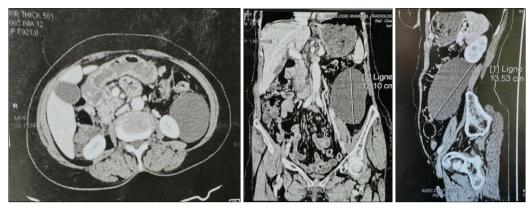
Abdominal CT scan showing a left retroperitoneal cystic mass.
